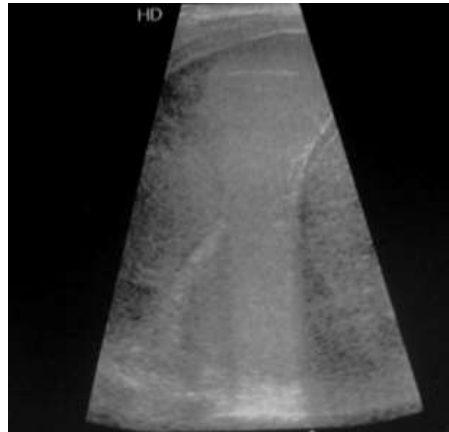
(A) Chest radiograph shows massive left pleural effusion. (B) Ultrasound demonstrates stage 2 parapneumonic effusion hence pigtail drain with fibrinolysis agent was introduced (C).
